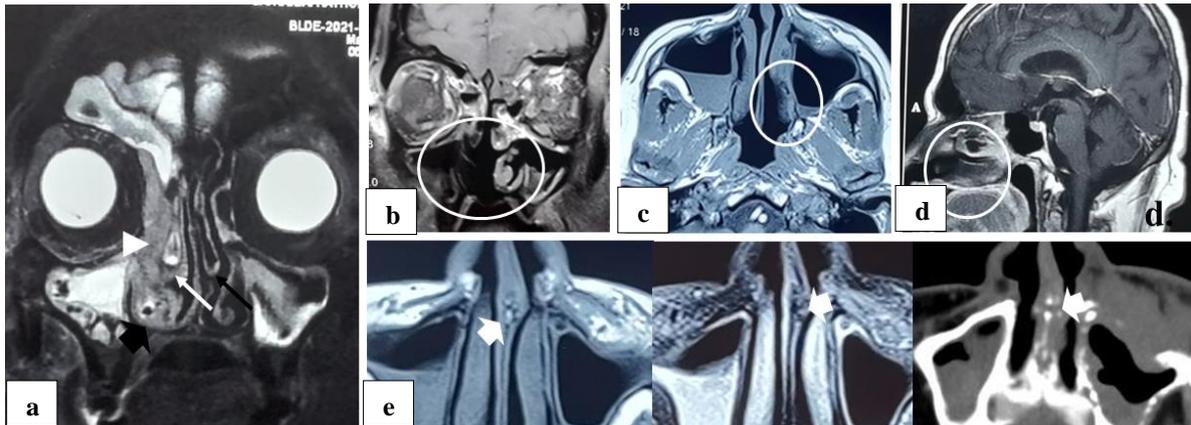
Nasal changes; bilateral concha bullosa (black-arrow) with fluid filled (white-arrow), enlarged inferior turbinate (thick-black-arrow) and obliteration of right OMC (white-arrowhead); “black turbinate” sign (white-circle); T1W, T2W and contrast enhanced CT of fungal mycetoma (thick-white-arrow).
